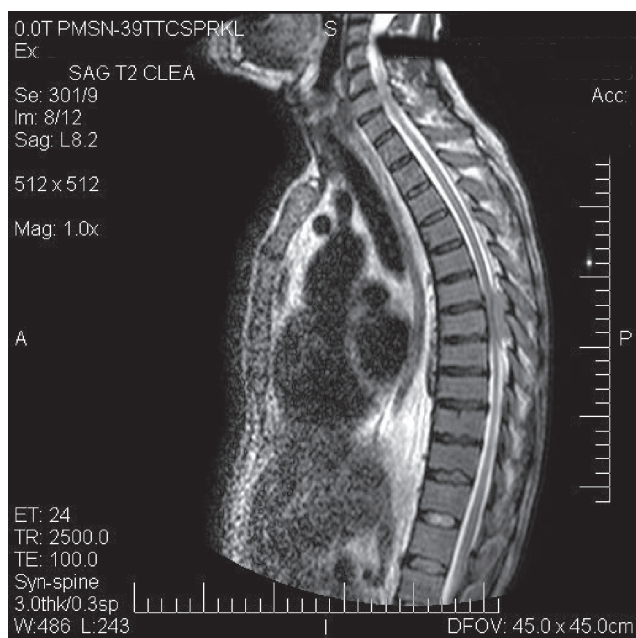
T2-weighted sagittal magnetic resonance image showing a hyperintense extradural lesion at the eighth thoracic spinal segment
